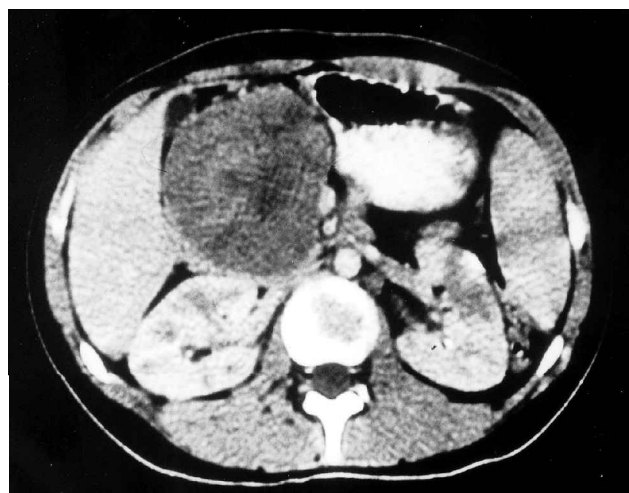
CT scan showing a mass occupying the region of the hepatic hilum, extending towards the head of pancreas and appearing to involve it.
